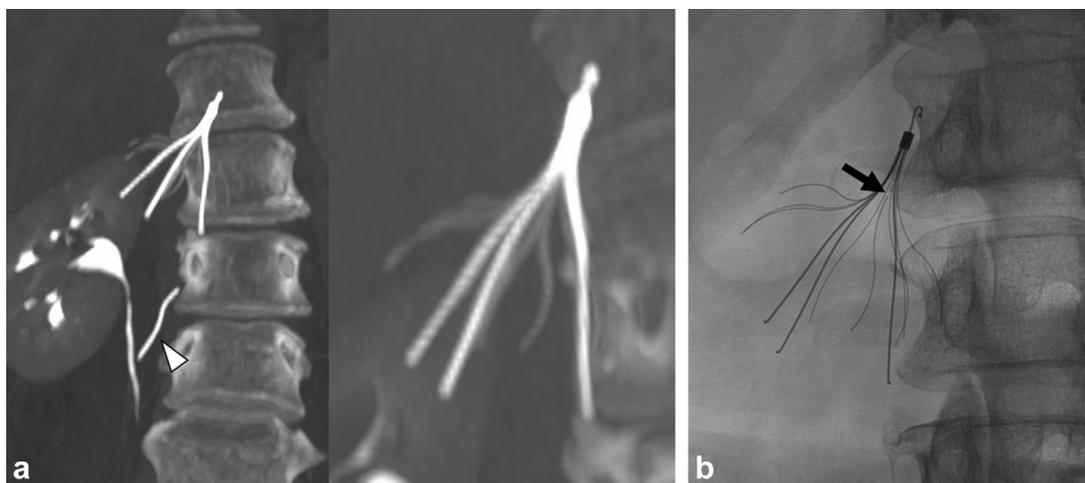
(a) Curved coronal CT images using maximum intensity projection show a tilted and deeply embedded Celect IVC filter, as well as a fractured filter leg that migrated caudally in the right retroperitoneum, passing through the right psoas muscle (white arrowhead). No other filter fracture was visualized on the CT. (b) Magnification spot radiograph (left anterior oblique) of the filter acquired just before the removal procedure, 10 weeks after the CT scan, show an additional minimally displaced leg fracture (black arrow). This fracture is not visible on the other magnification spot radiographs or on the CT, even in retrospect. The main body of the filter and the minimally displaced fracture fragment were successfully removed using endobronchial forceps. The distal retroperitoneal fragment was extravascular, and removal was not attempted.
